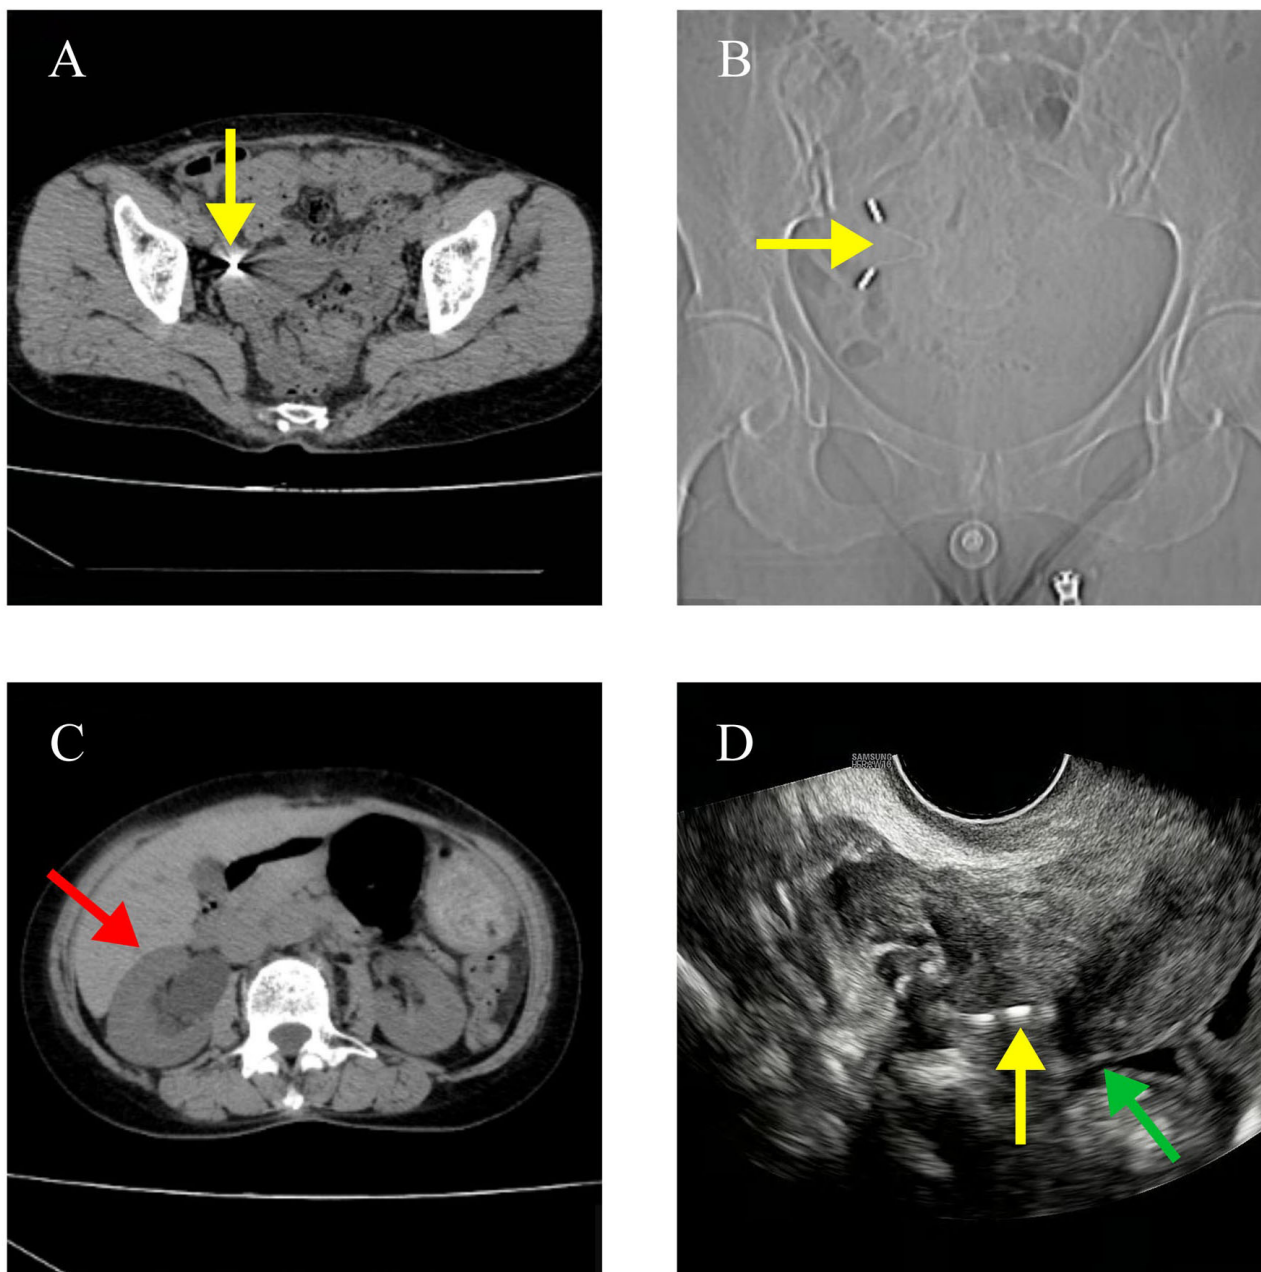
CT and ultrasound findings of the patient. (A) Axial CT image demonstrating a hyperdense shadow (arrow) in the right adnexal region. (B) Coronal reconstructed CT image showing the corresponding V-shaped hyperdense structure (arrow) in the right adnexa. (C) Axial abdominal CT image showing right-sided renal pelvis dilation and fluid accumulation (arrow). (D) Transvaginal pelvic ultrasound demonstrating partial IUD-like echo (likely representing a V-shaped Ai Mu IUD) was visible in the right uterine horn muscle layer (yellow arrow), approximately 10 mm in the muscle layer, with a two-arm-like echo seen in the right adnexal region. The green arrow indicates the uterine horn. CT, computed tomography; IUD, intrauterine device.
